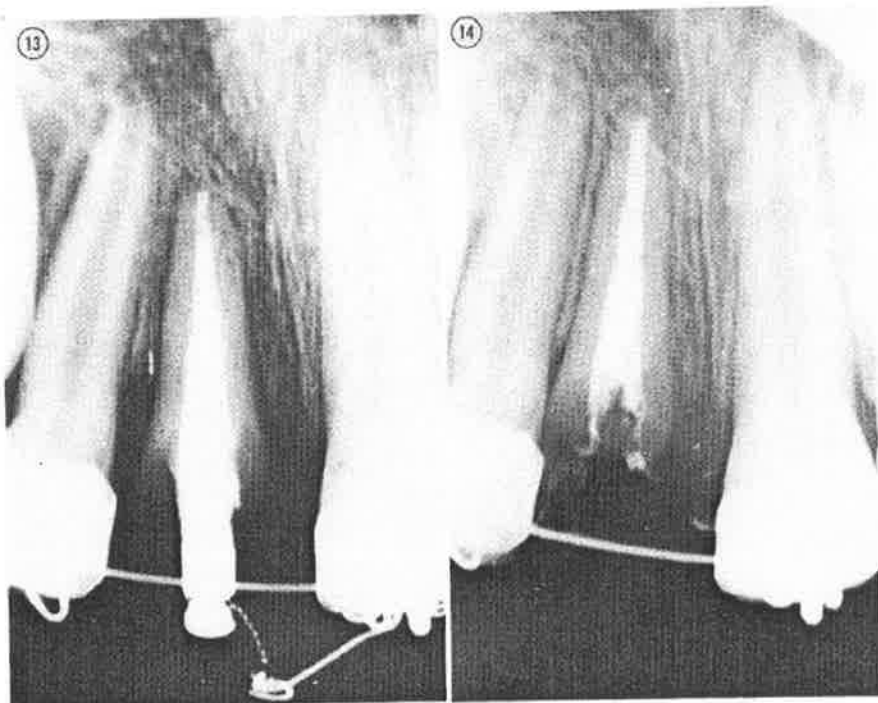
Case 2. Radiograph showing the root after it had been moved incisally a distance of 3 mm.
